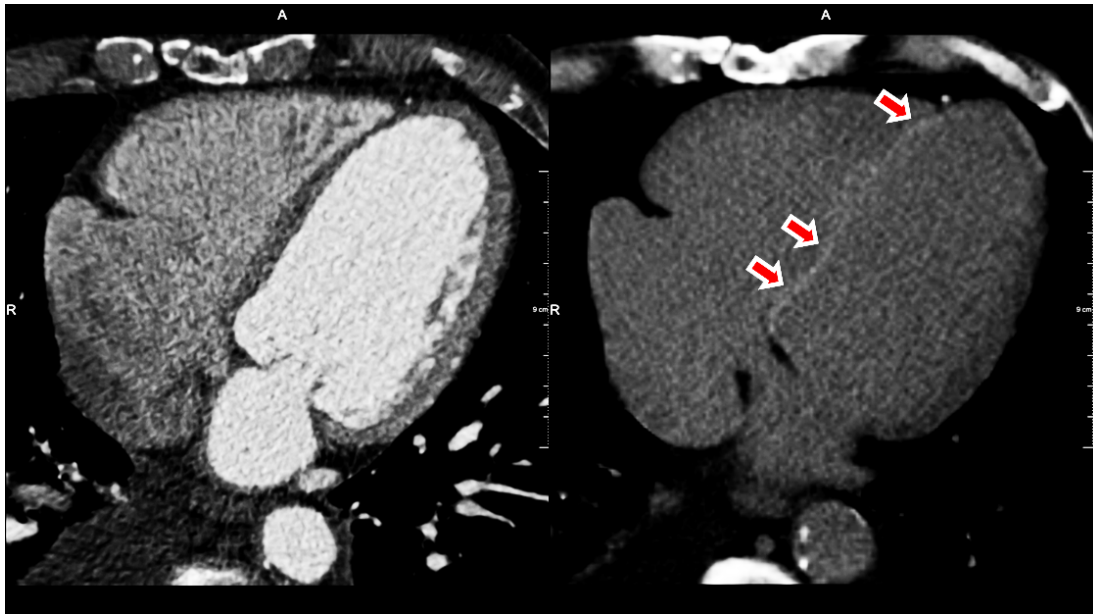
Corresponding slices in a CT coronary angiography and a late enhancement CT image. The arrows point at the infarcted myocardium (image data courtesy of Prof. A. Mahnken, University Hospital Aachen).
